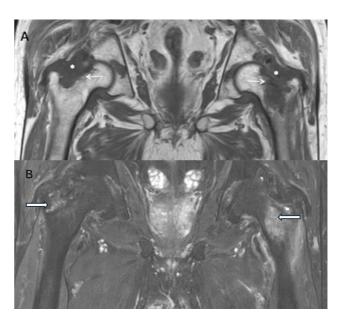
Coronal (A) T1 turbo spin echo (TSE) and (B) T2 TSE fat-saturated magnetic resonance images show hypointense bilateral synovial thickening and hypertrophy (*asterisks* in A) in bilateral hip joints, more on the left side. The thickened synovium is causing marked pressure scalloping and erosions over the adjoining cortex of the bilateral femoral head, neck, and trochanteric regions and the acetabulum (*thin arrows* in A). Abnormal bone marrow edema is also noted in the adjoining part of the bilateral femoral neck and trochanteric regions (*thick arrows* in panel B).
